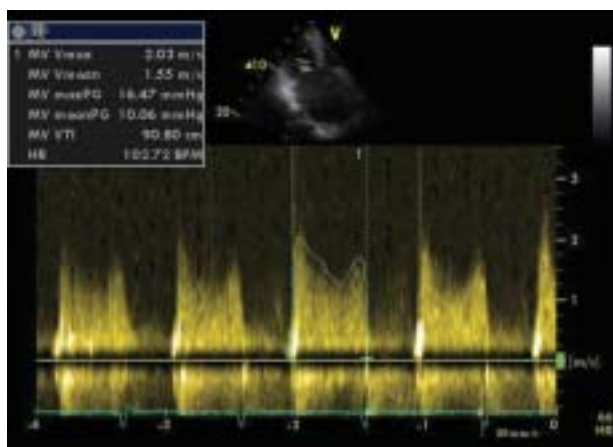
Apical transthoracic view. Increased transmitral systolic pressure gradient
